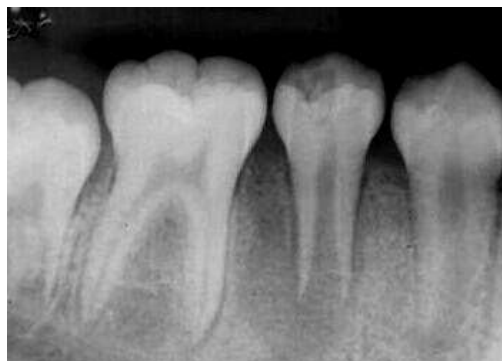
Radiographic appearance - incomplete rhizogenesis
